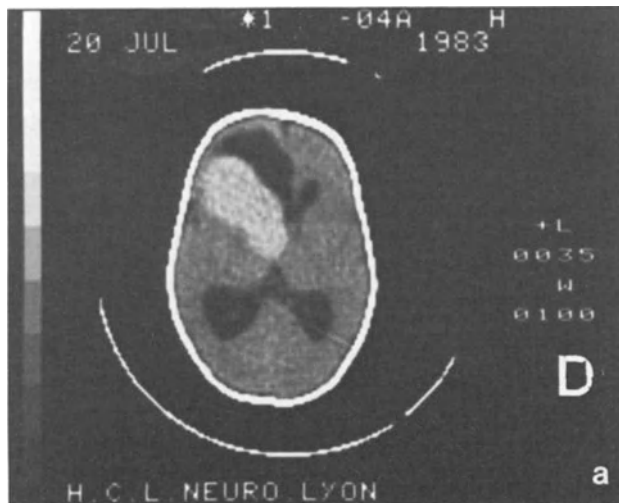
Grade III infantile ependymoma with trapped frontal horn. a) Pre-contrast CT. b) Post-contrast CT
